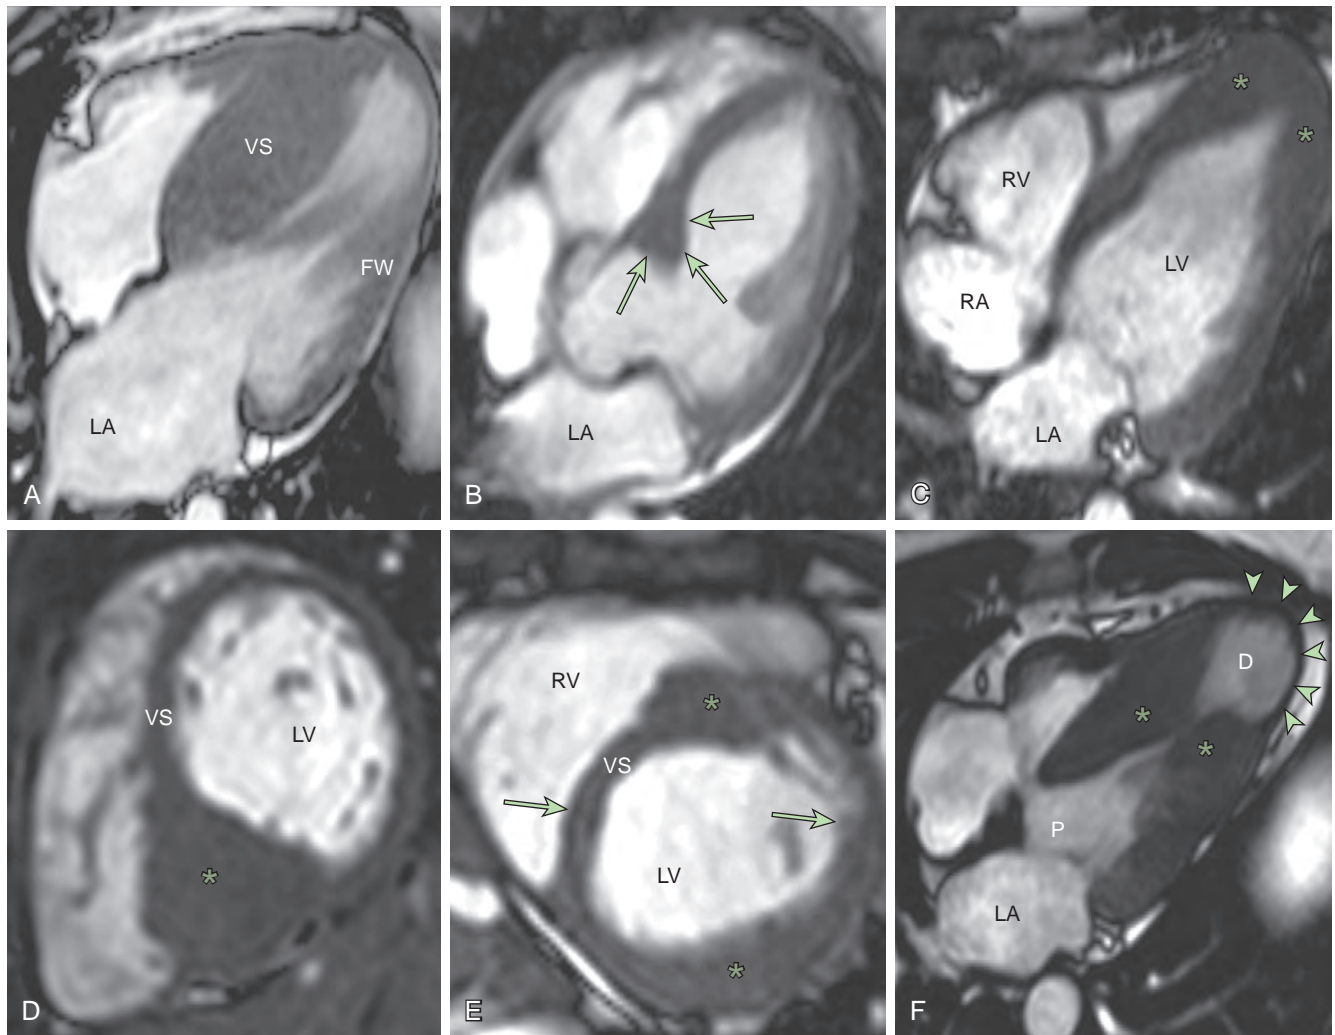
Cardiac magnetic resonance images of the phenotypic variants of hypertrophic cardiomyopathy. (A) Diffuse hypertrophy of the interventricular septum with sparing of the left ventricular free wall. (B) Isolated basal septal hypertrophy (arrows). (C) Apical hypertrophy (asterisks). (D) Posterior left ventricular septal hypertrophy (asterisk). (E) Discontinuous hypertrophy of the basal anterior septum (uppermost asterisk) and the posterior free wall (lower asterisk) separated by regions of normal left ventricular wall thickness (arrows). (F) Midventricular hypertrophy (asterisks), dividing the left ventricular chamber into proximal (P) and distal (D) segments with an apical pouch (arrowheads). D, Distal (apical) left ventricle; FW, free wall; LA, left atrium; LV, left ventricle; P, proximal left ventricle; RA, right atrium; RV, right ventricle; VS, ventricular septum. (Reproduced with permission from Maron BJ, Maron MS. *Hypertrophic cardiomyopathy*. Lancet. 381:242–255.)
